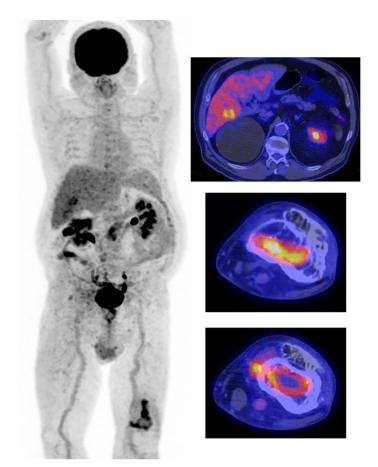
Example of a FDG-PET scan (left: MIP image, right transversal fused FDG-PET/CT images) of a patient with an osteomyelitis of the distal left femur with spread of infection in the soft tissue around the bone, and spread of infection to the liver.
